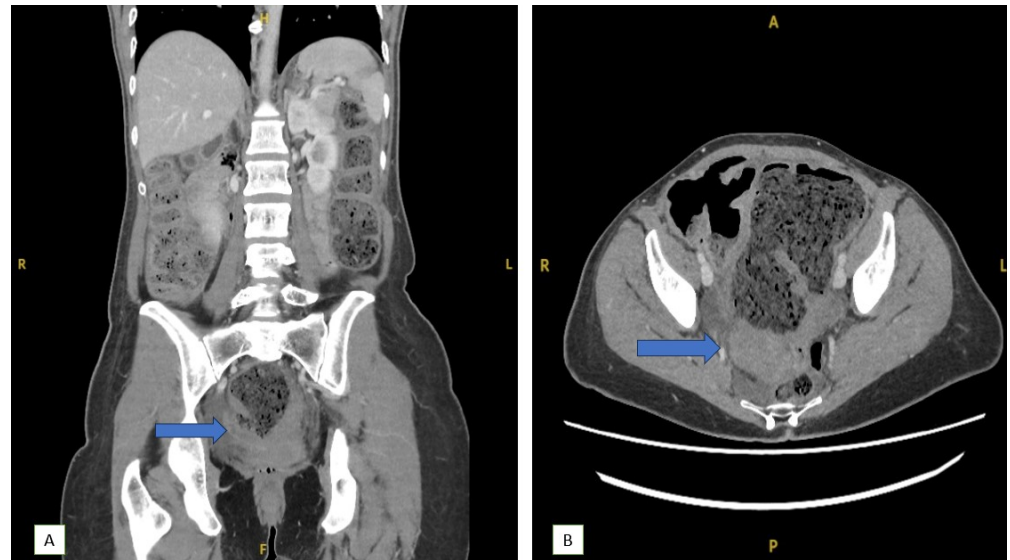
Computerised tomography (CT) showing soft tissue mass (blue arrow) with upstream large bowel obstruction in (A) Coronal and (B) Axial sections. H, head; F, foot; L, left; R, right; A, anterior; P, posterior.
